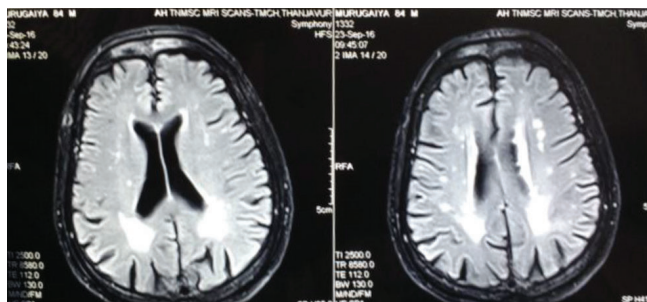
84 years old male patient presented with complaints of seizures since 4 months. There was also history of frequent falls. MRI showed periventricular hyperintensities s/o small vessel disease
